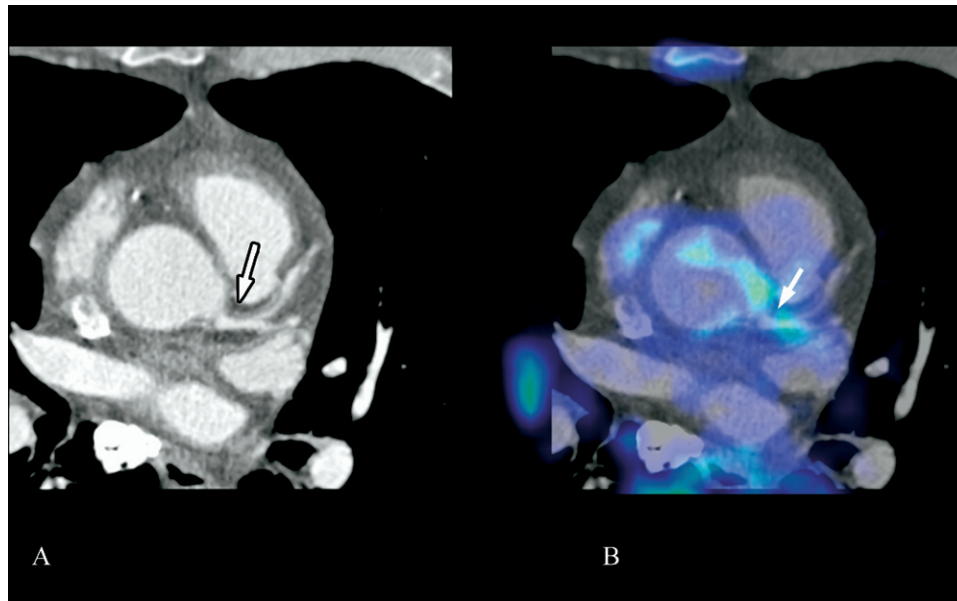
CCTA image of noncalcified plaque in left main coronary artery (A) (arrow) and corresponding image after fusion with F-18 FDG-PET/CT (B), localizing the inflammatory PET signal with a maximal standard uptake value of 2.1 to the noncalcified plaque seen in the left coronary artery (arrow).
